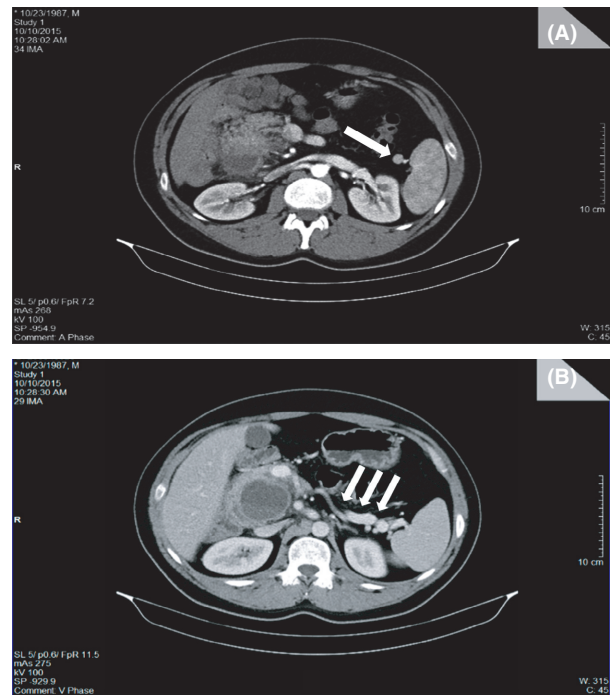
(CT scan): (A) Presence of the ectopic spleen (white arrow); (B) Cut showing the absence of pancreatic tissue anterior to the splenic vein, where it is usually located (white arrows).
